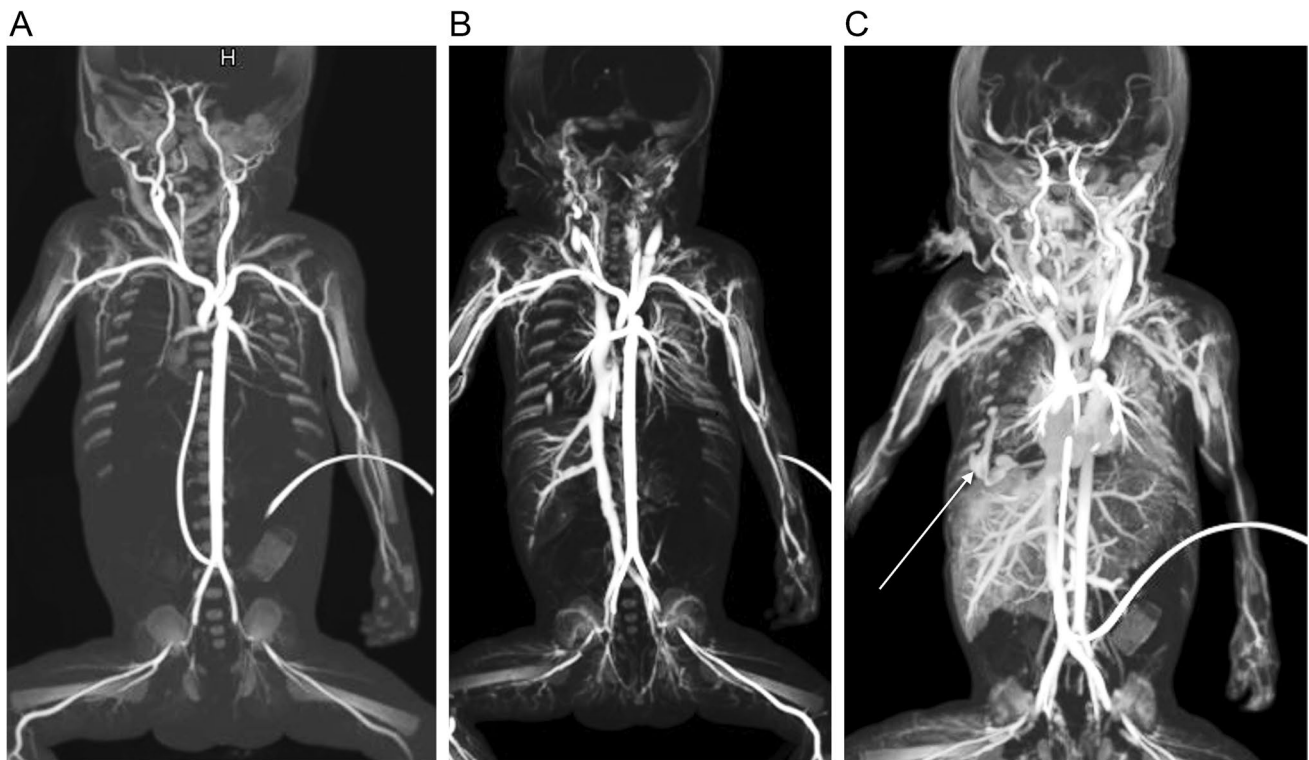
A 2-day-old premature girl of 700 g who developed acute onset respiratory insufficiency requiring cardiopulmonary resuscitation that was unsuccessful. There was a large amount of fresh blood from the mouth and nose, suspected to be due to pulmonary hemorrhage. The parents consented to postmortem imaging but not autopsy. Computed tomography angiography was performed. An initial unenhanced scan without contrast was performed (not shown). a Coronal maximum intensity projection (MIP) image obtained 1 min after
